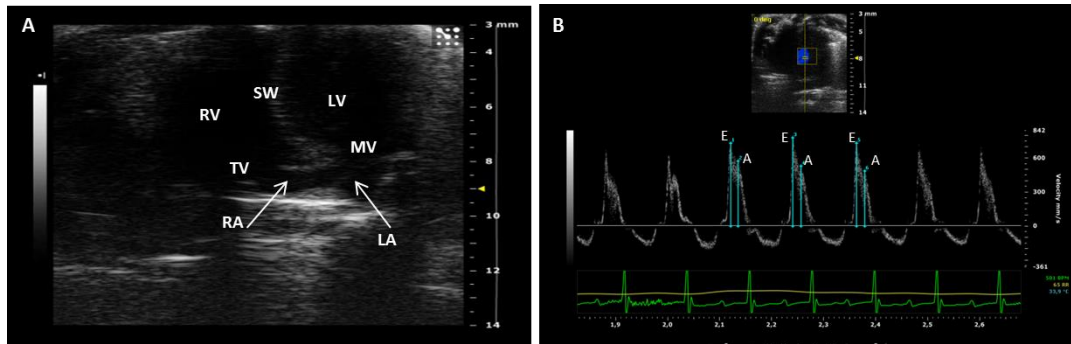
Echocardiographic image recoding and cardiac diastolic function analysis
